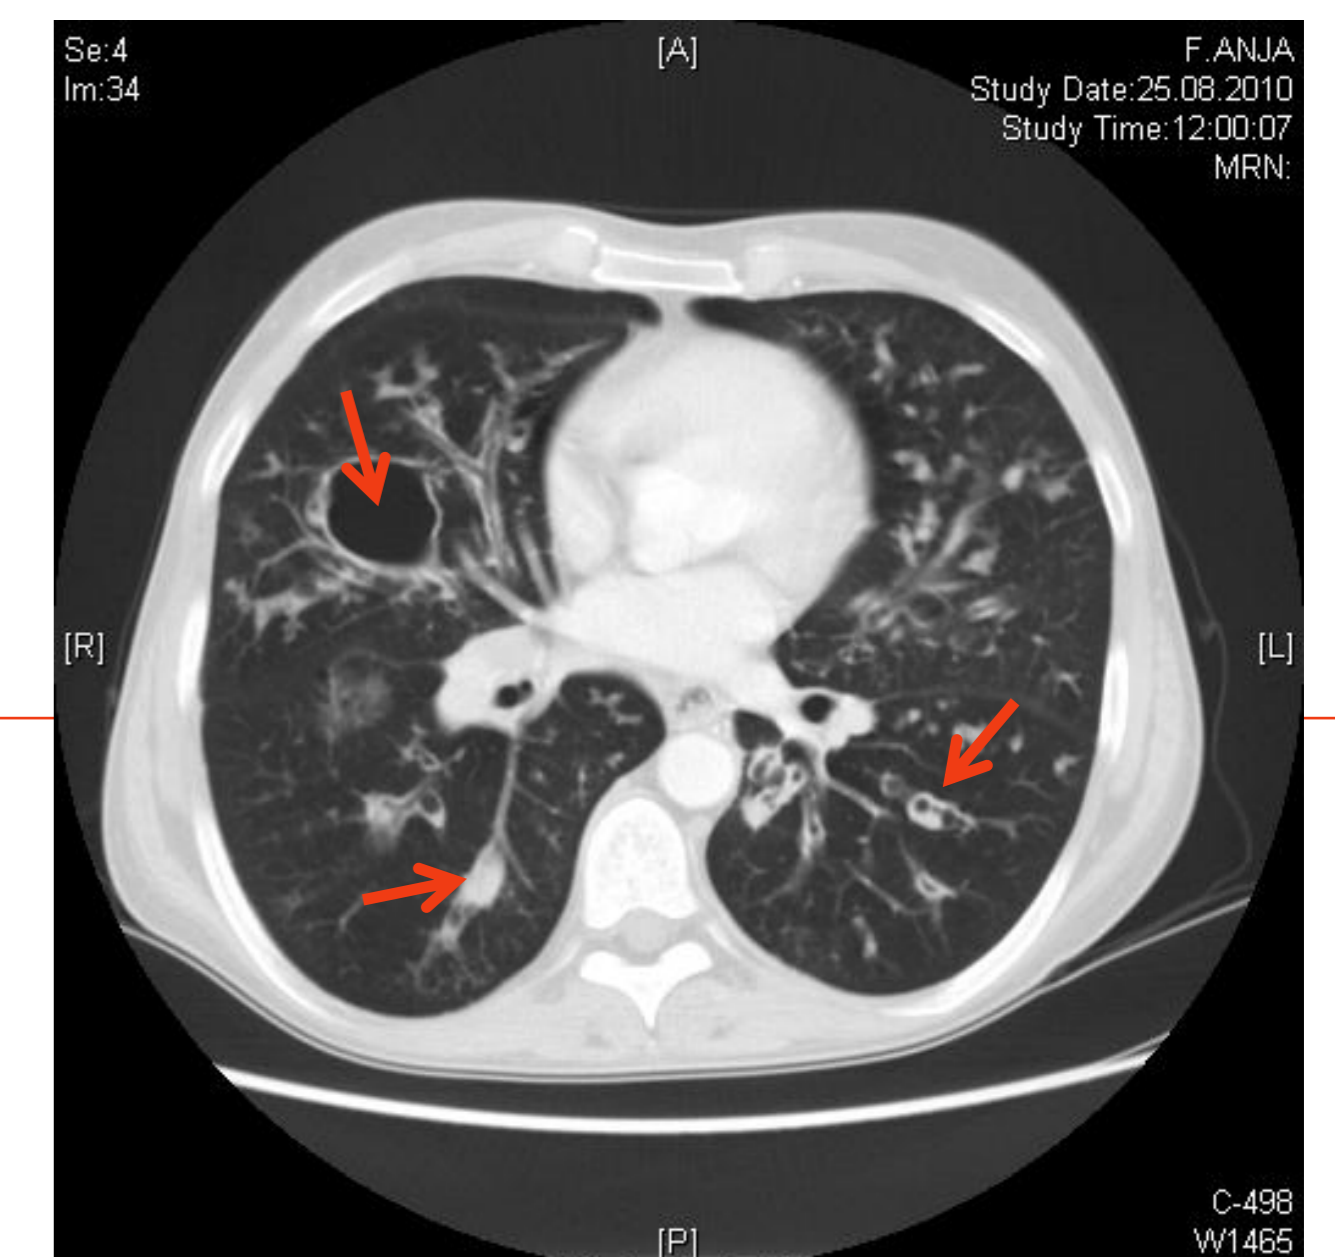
bronchiectasis, small nodules and bronchial swelling on HRCT.
